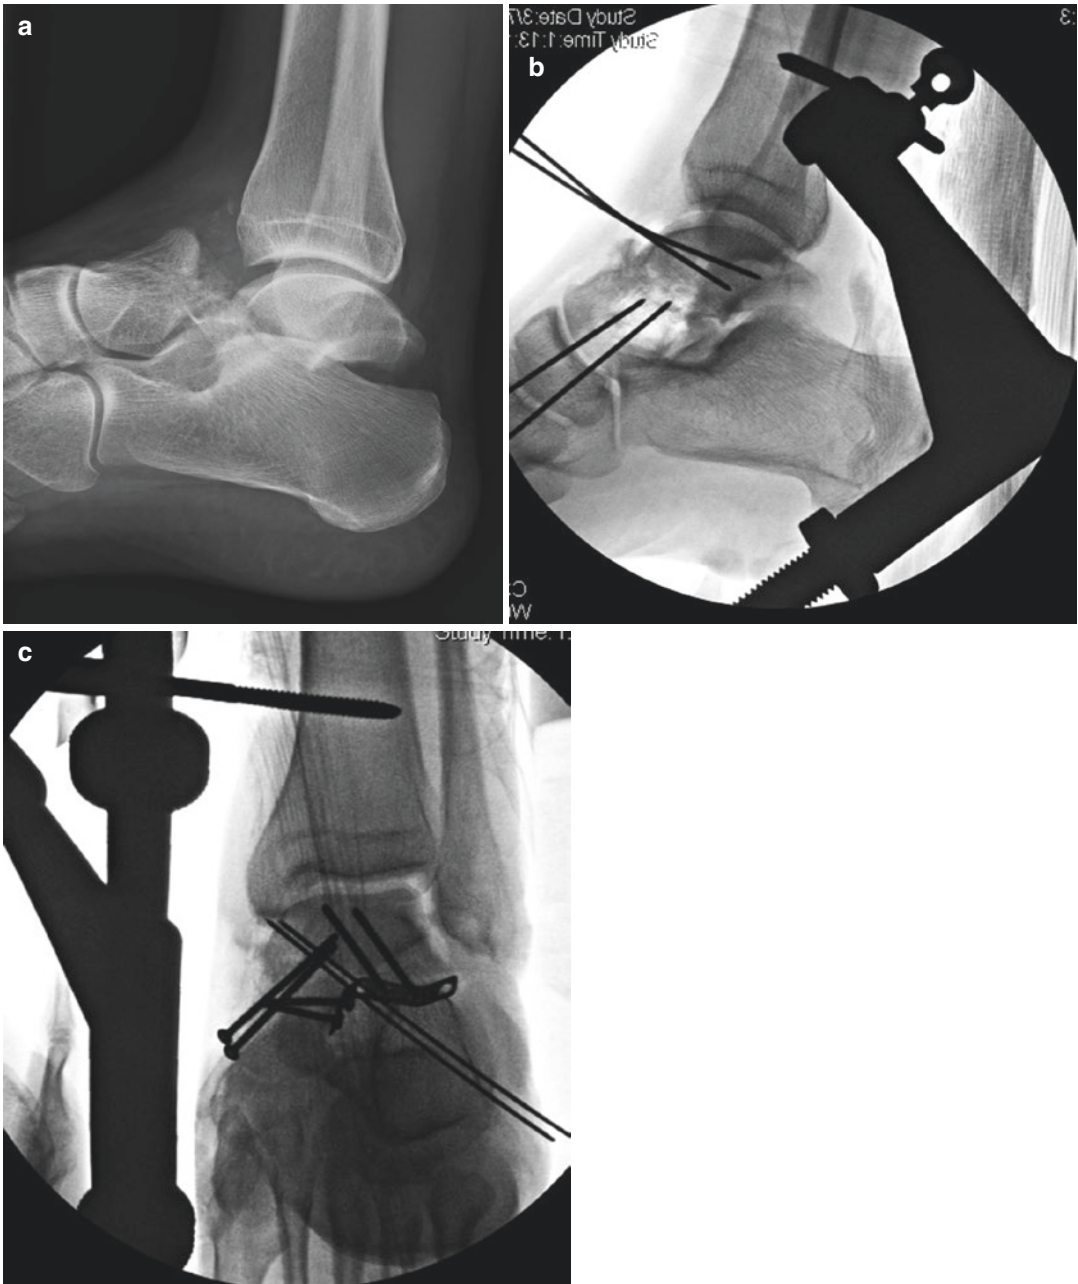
Lateral ankle radiograph shows a talus fracture dislocation (a). Often, the talar body will be displaced posteromedially and will not be reducible via closed means. Reduction of the body is prohibited by intervening capsule and by the adjacent posterior tibialis and long toe flexor tendons. Urgent reduction in the operating room is recommended. An anteromedial exposure provides access to the ankle and subtalar joints, with the talar body still displaced. Intraoperatively, a universal distractor may be
